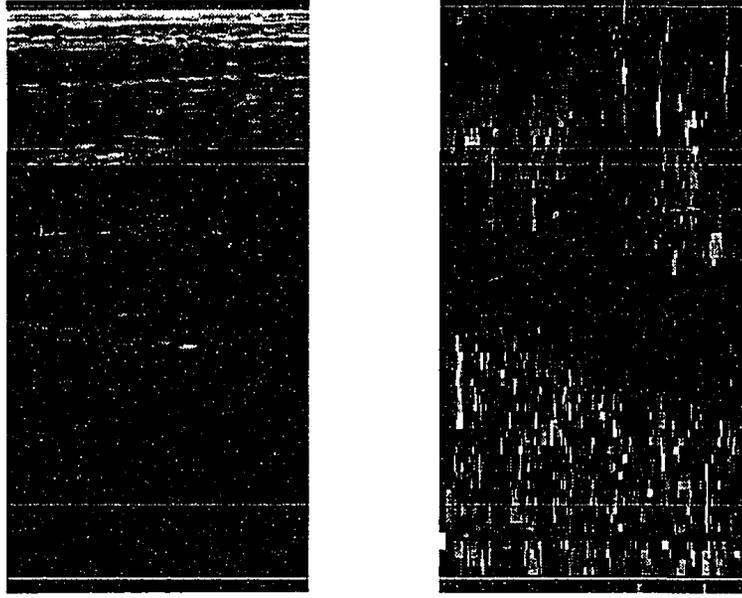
Sagittal ultrasound and strain images of Achilles' tendon.
